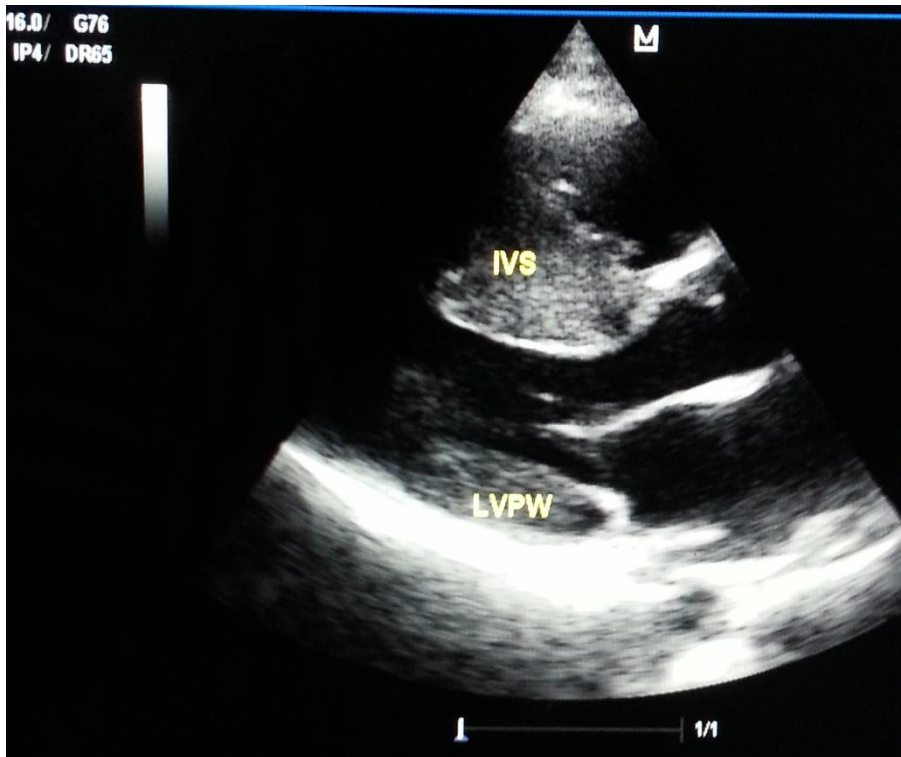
Parasternal long axis view showing markedly hypertrophied left ventricular septum in comparison to the posterior wall.
